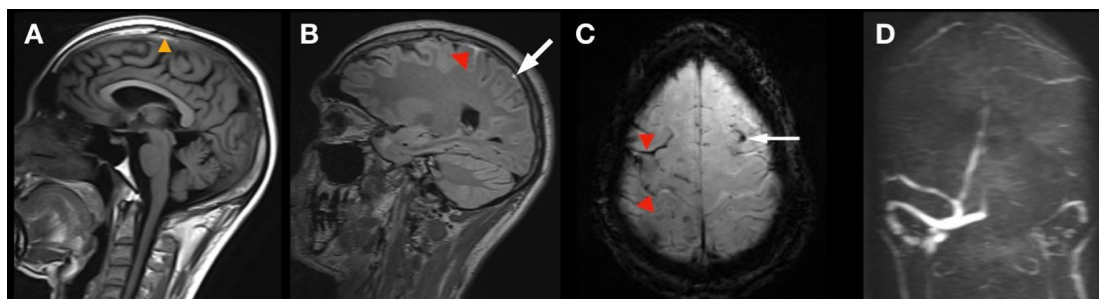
Representative images of cSAH. MRI Brain of a 36-year-old man diagnosed with CVT. A: T1W image showing hyperintensity in superior sagittal sinus (yellow arrowhead). B, C: T2 FLAIR and SWI images showing fronto-parietal cortical surface hyperintensity extending into the sulcus with gradient blooming suggestive of cSAH (red arrowheads), dot-like hyperintensity with gradient blooming suggestive of thrombosed cortical veins (white arrow). D: MRV showing absence of flow related hyperintensity in superior sagittal sinus, left transverse sinus and cortical veins.
